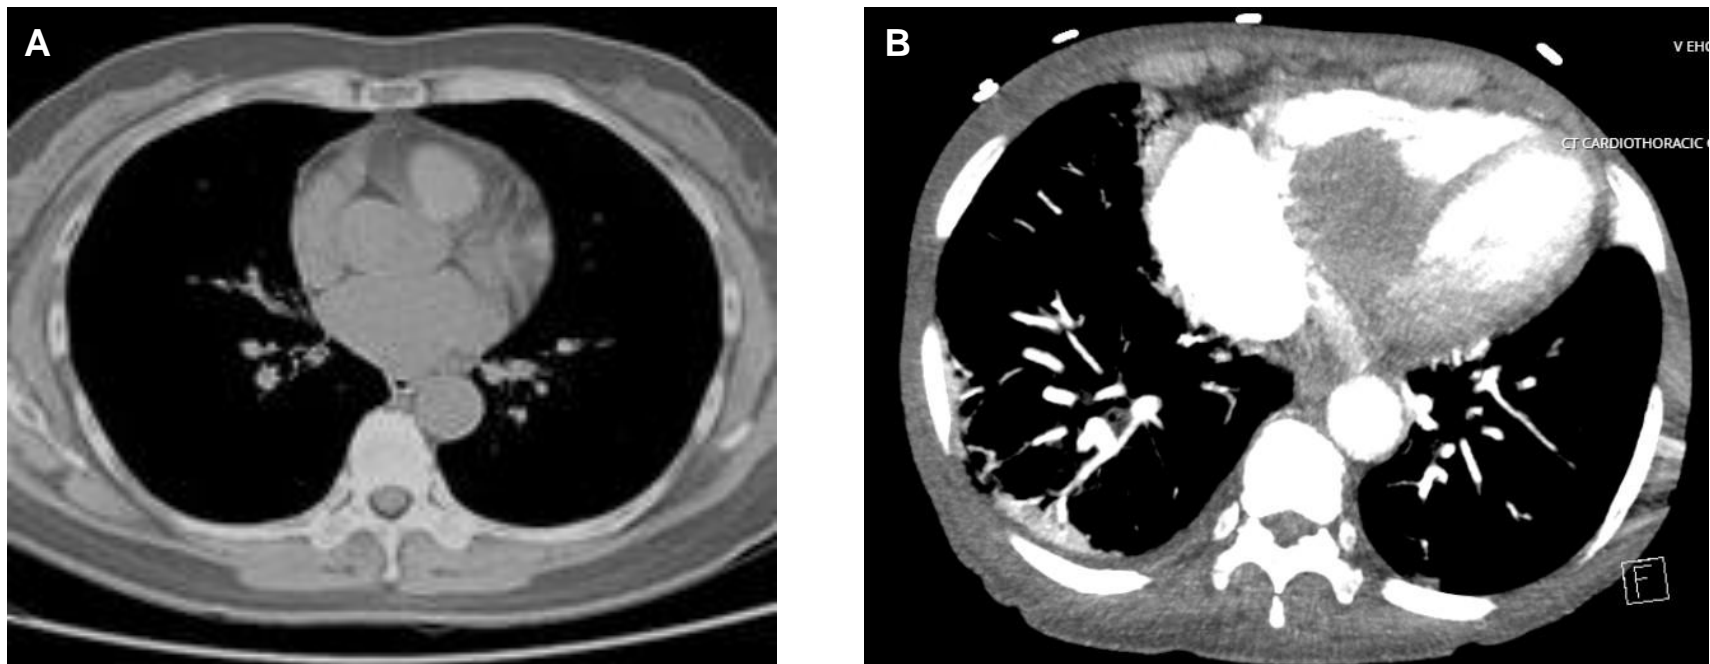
Normal thoracic CT scan (A) and CT scan of invasive myocardial tumor discussed in presented case (B).
